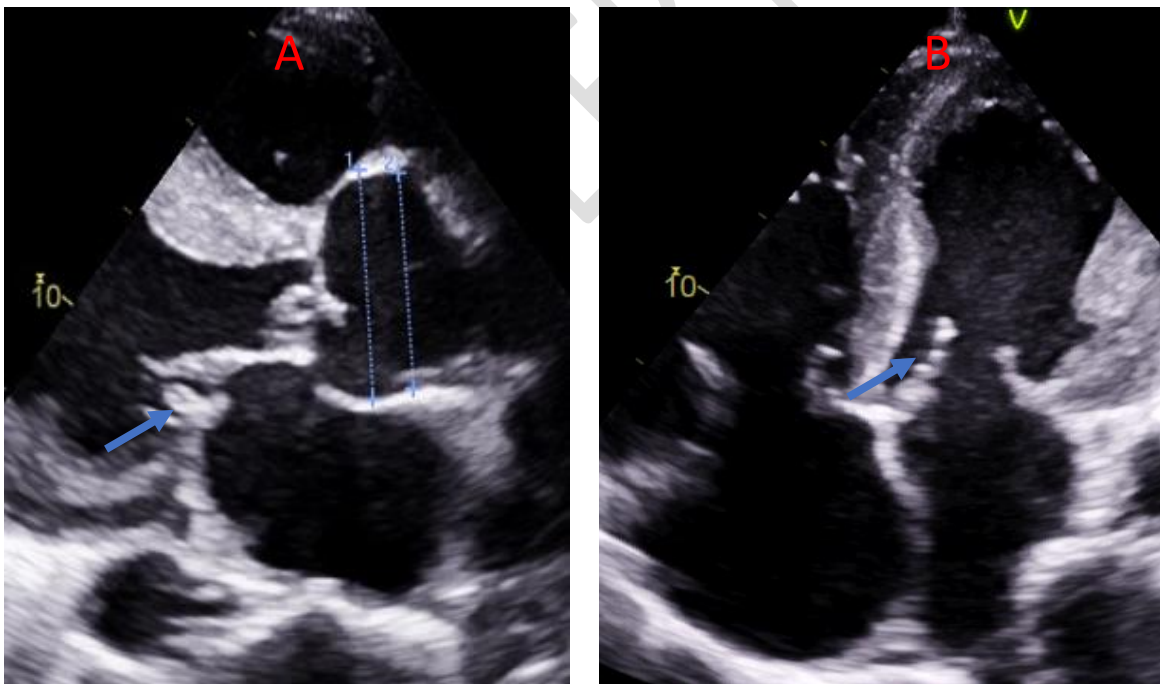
TTE: long-axis parasternal view: A- thickened mitral valve, remodeled, site of an echogenic formation (vegetation) mobile located on the small mitral valve
